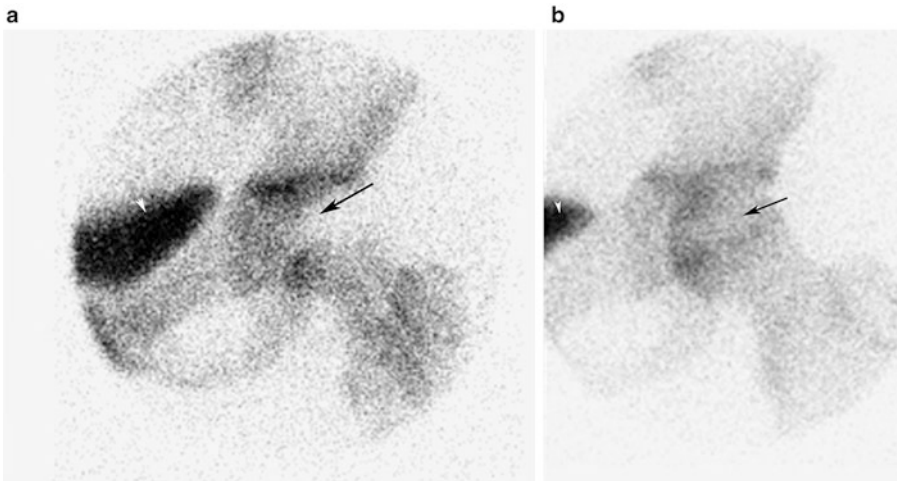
(a) AP pinhole collimated image of the left hip from a bone scintigraphy study on a 6-year-old patient 4 days s/p open reduction and internal fixation of the left hip for femoral neck fracture demonstrates no perfusion to the femoral head (*black arrow*). The *white arrowhead* denotes the bladder. (b) AP pinhole collimated image of the left
